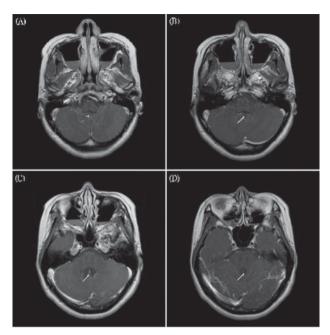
MRI (T1WI with contrast) of brain on February 16, 2011 showed no tumor mass over 4th ventricle.
